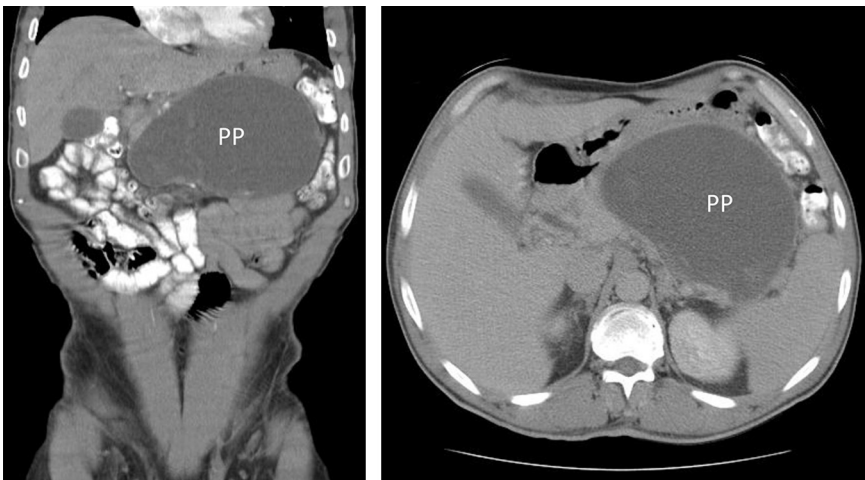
CT images demonstrating uncomplicated retrogastric pancreatic pseudocyst, amenable to surgical or endoscopic intervention.
